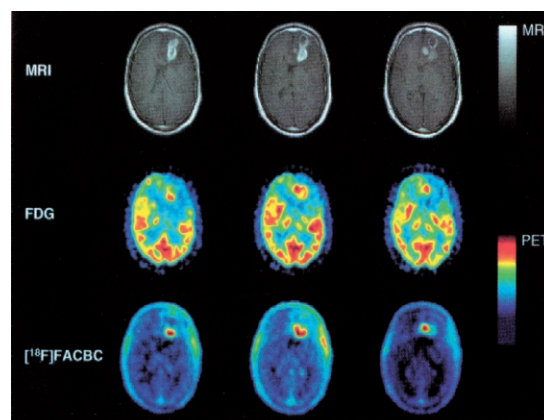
^{18}F -FACBC-PET images of patient with glioblastoma multiform (bottom row). Top row: T1-weighted transaxial MRI scans with gadolinium enhancement. Middle row: ^{18}F -FDG-PET images. (Data from reference¹¹⁾).
